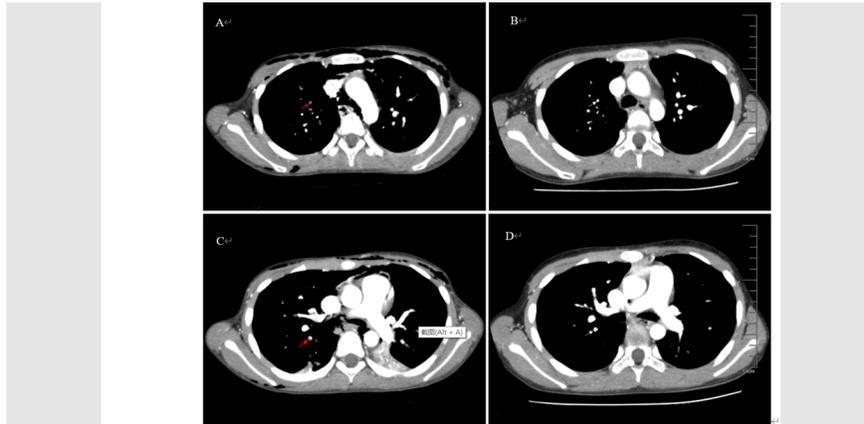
Image changes of chest contrast-enhanced CT on the 4th day of admission and 1-month follow-up after discharge. A B Red arrow pointed pulmonary emboli. C D Pulmonary emboli disappeared at the same position.
